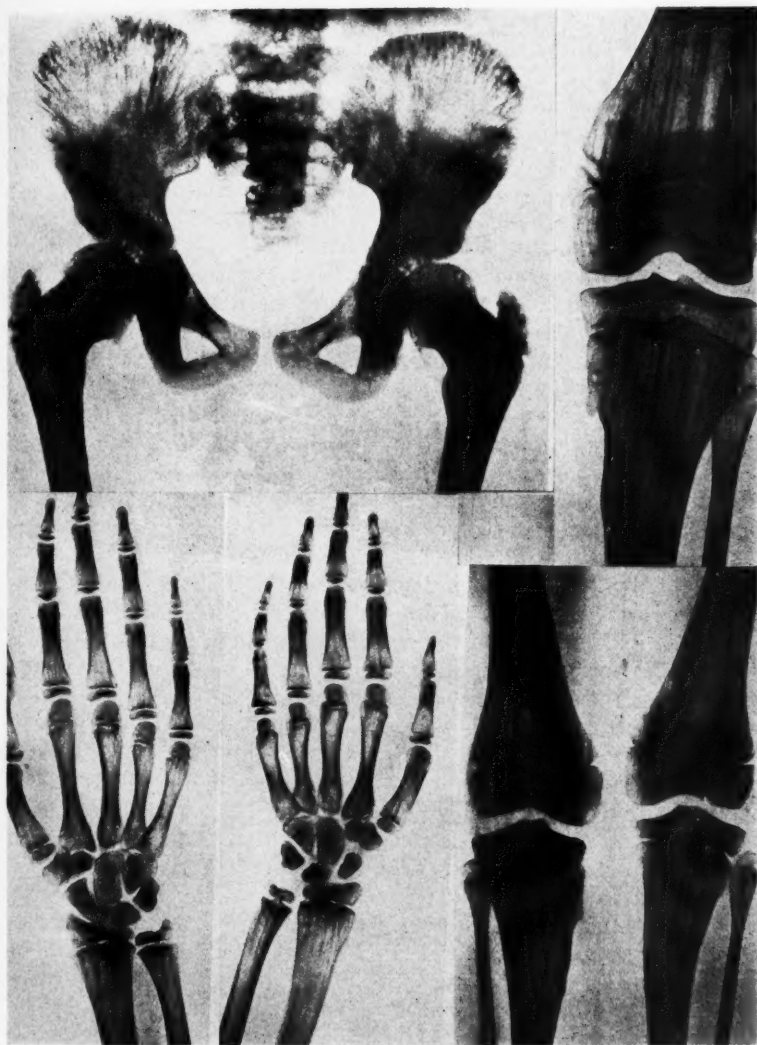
Osteopoikilosis. Roentgenograms from case reported by Voorhoeve (*Acta Radiologica*, 1924, 3, 407. *Reproduced by courtesy of that Journal.*)
